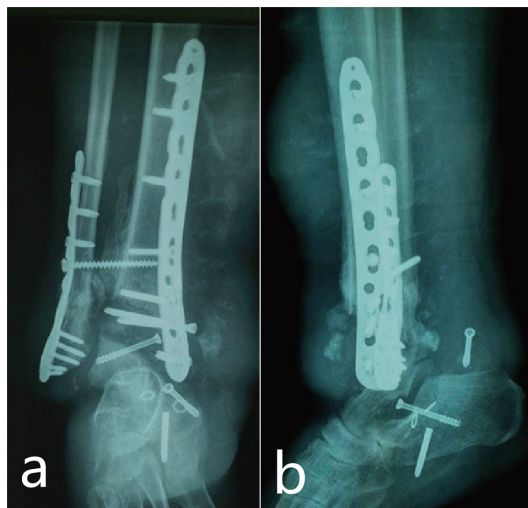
Radiographs 6 months after ORIF (open reduction and internal fixation) showing bone resorption of the distal tibial articular surface and talus, significantly loosening of internal fixation, and fracture of a locking screw
